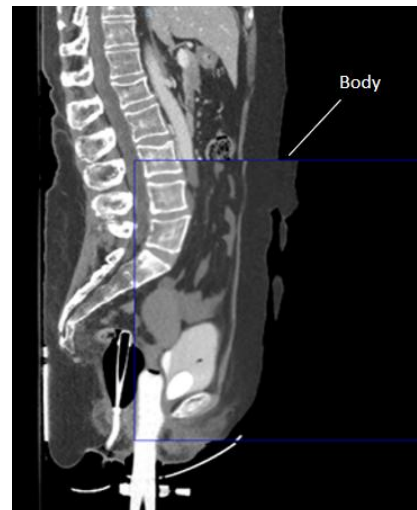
Sagittal CT image showing the delineation of the body.
